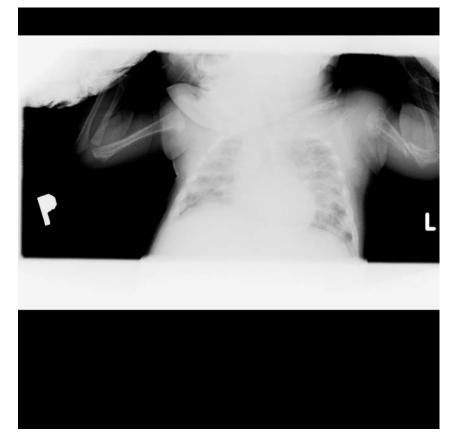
The X-ray revealed the fracture of the humerus with bone displacement
